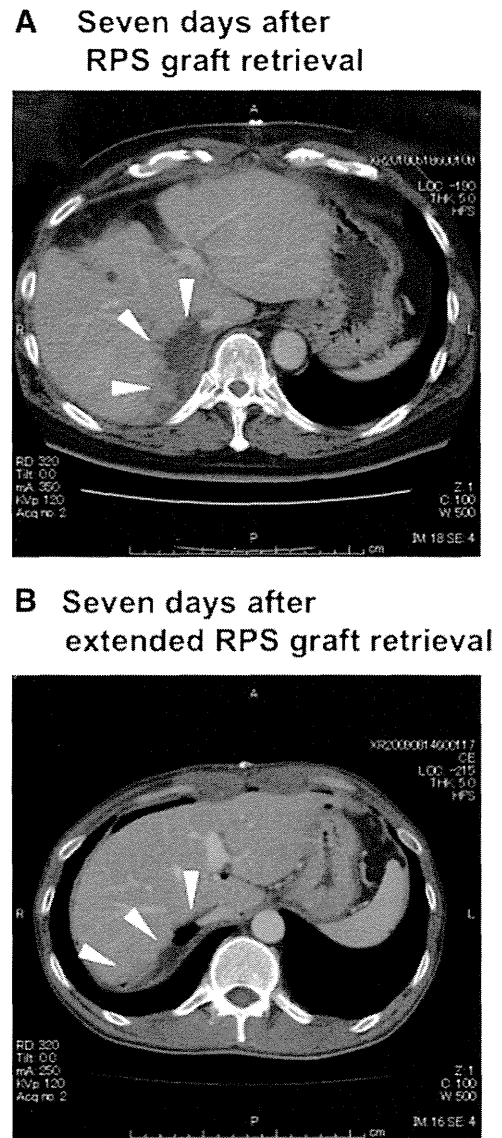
Representative enhanced CT 7 days after donor hepatectomy. (A) From this donor, an RPS graft was retrieved (case 4). The remnant liver had an unevenly cut surface (arrowheads). (B) From this donor, an extended RPS graft was retrieved (case 2). The cut surface of the remnant liver was straight (arrowheads).
